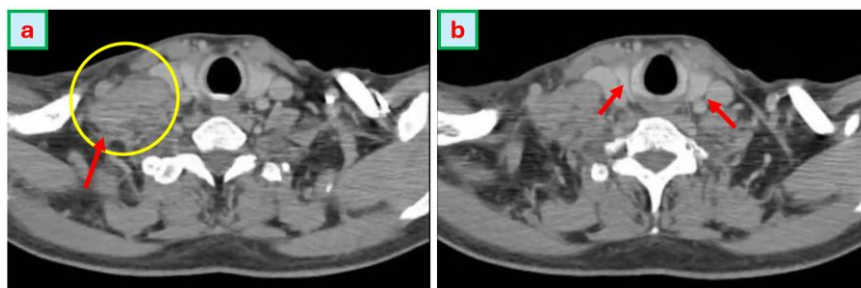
Neck CT scan with Contrast
